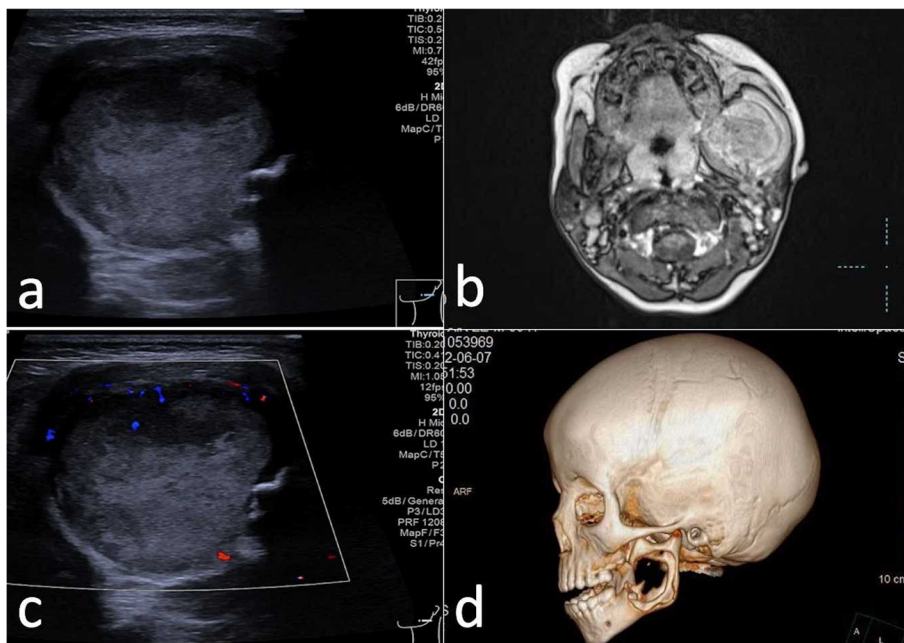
Imaging in a child with SS-LCH who had a single lesion in the left mandible. a Bone defect area with irregular margins and internal solid hypoechoogenicity. b CDFI examination showed a few short streaks of blood flow signal within the lesion. c MR T1W1 enhanced scan showing a mass in the left mandible with significant enhancement and peripheral bone destruction. d Three-dimensional CT reconstruction imaging showing osteolytic destruction of the mandibular angle to the ascending mandibular branch
